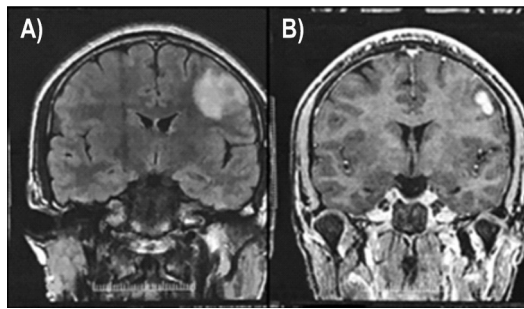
The MRI of brain with contrast done in Fortis Hospital Limited in Mumbai, India on 06 January 2020. A, B) On both slides in frontal section at different degrees of depth left frontal lobe with persistent small well-defined heterogeneously enhancing conglomerate lesion (measured 9x10 mm in axial and 15.5 mm in cranio-caudal dimension) with surrounding mild perilesional oedema with minimal blooming in gradient is depicted
